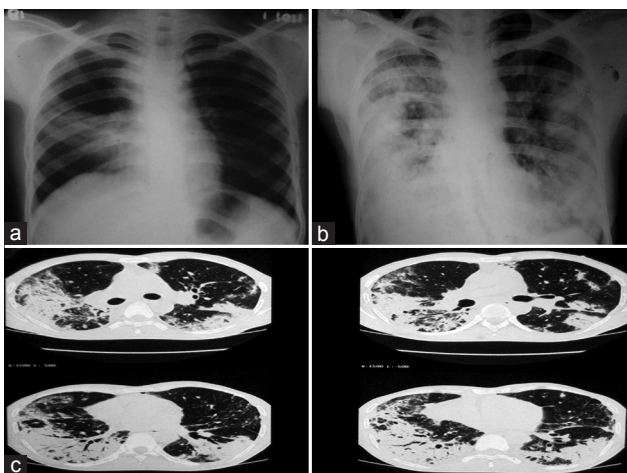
Chest X-ray PA view showing right lower zone alveolar opacity before starting antitubercular drug (ATD) (a) and bilateral peripheral consolidation in upper and mid zones of lung mimicking photographic negative of pulmonary edema after three weeks of starting ATD (b) High resolution computerised tomography of thorax showing bilateral diffuse air space opacification predominantly in the peripheral lung field along with some ground glass opacity suggestive of eosinophilic pneumonia (c)
